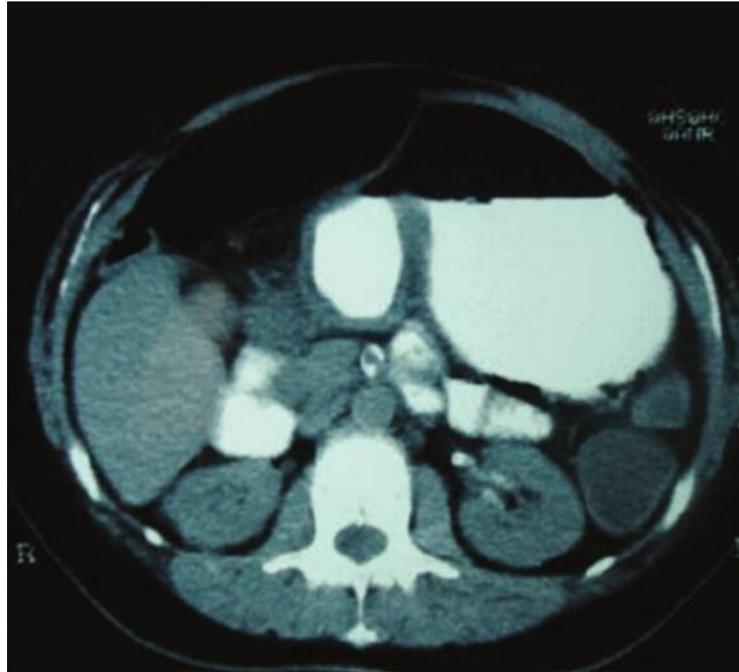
Axial CT image of stomach distended with oral contrast
